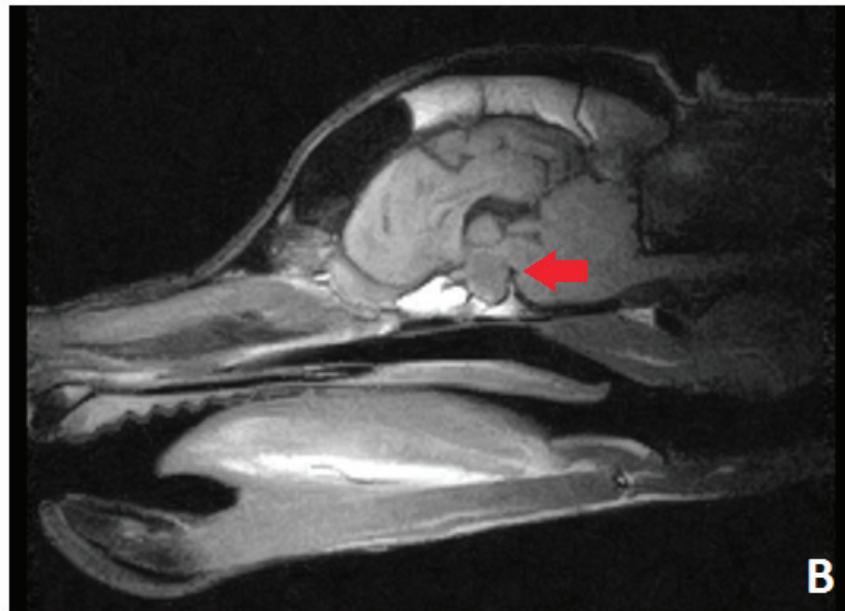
Magnetic resonance imaging of the skull.
